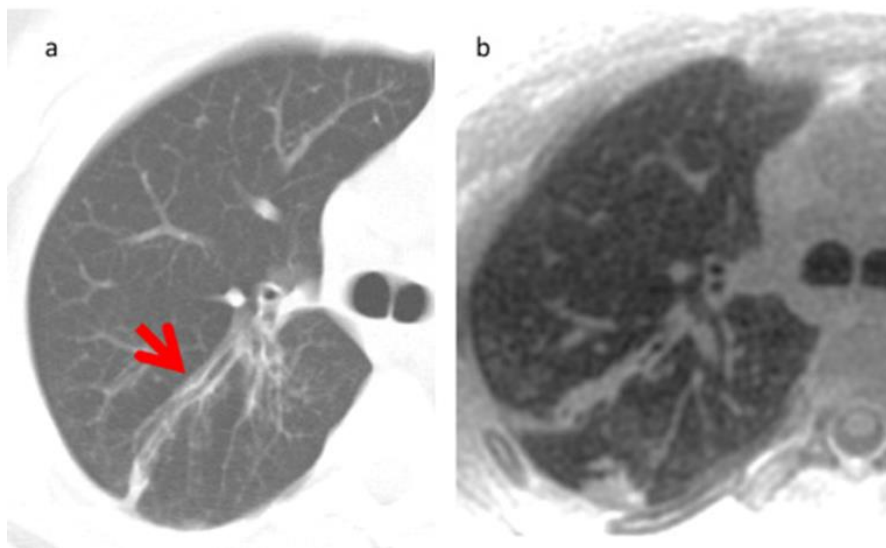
UTE MRI in cystic fibrosis. High-resolution computed tomography (HRCT) images (a) acquired 14 months prior to UTE MRI (b) in a 17-year-old with CF. Arrow indicates a region of bronchiectasis and mucus plugging well visualized on both HRCT and UTE MRI. Images were acquired using 3D radial UTE (Torres et al., 2019).
